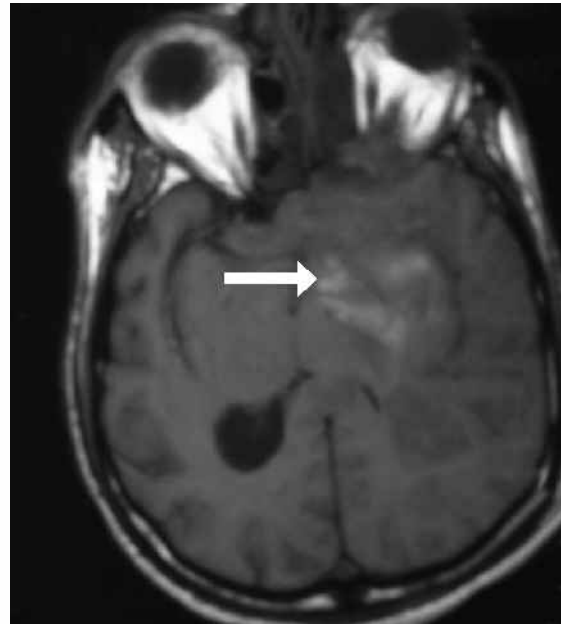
Axial T1-W MR image of the brain shows the intracranial mass (arrow) involving the left temporal lobe and left sphenoid sinus with midline shift
